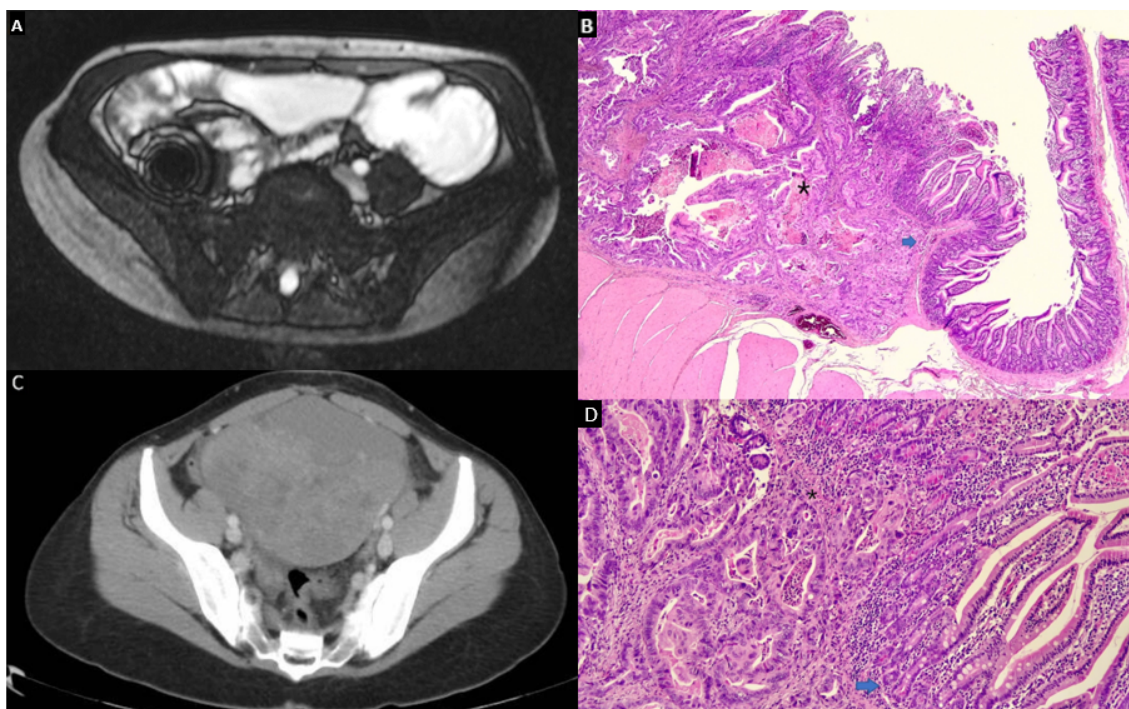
A. Abdominal magnetic resonance imaging (MRI) scan showed dilated loops and a stenotic area in the right lower quadrant. B and D. Moderately differentiated, infiltrating adenocarcinoma (asterisk) adjacent to normal small bowel mucosa (arrows) (HE 40x and 100x). C. Computed tomography (CT) scan showed a giant left ovarian mass (15 x 14 x 17 cm) with solid and cystic areas.
